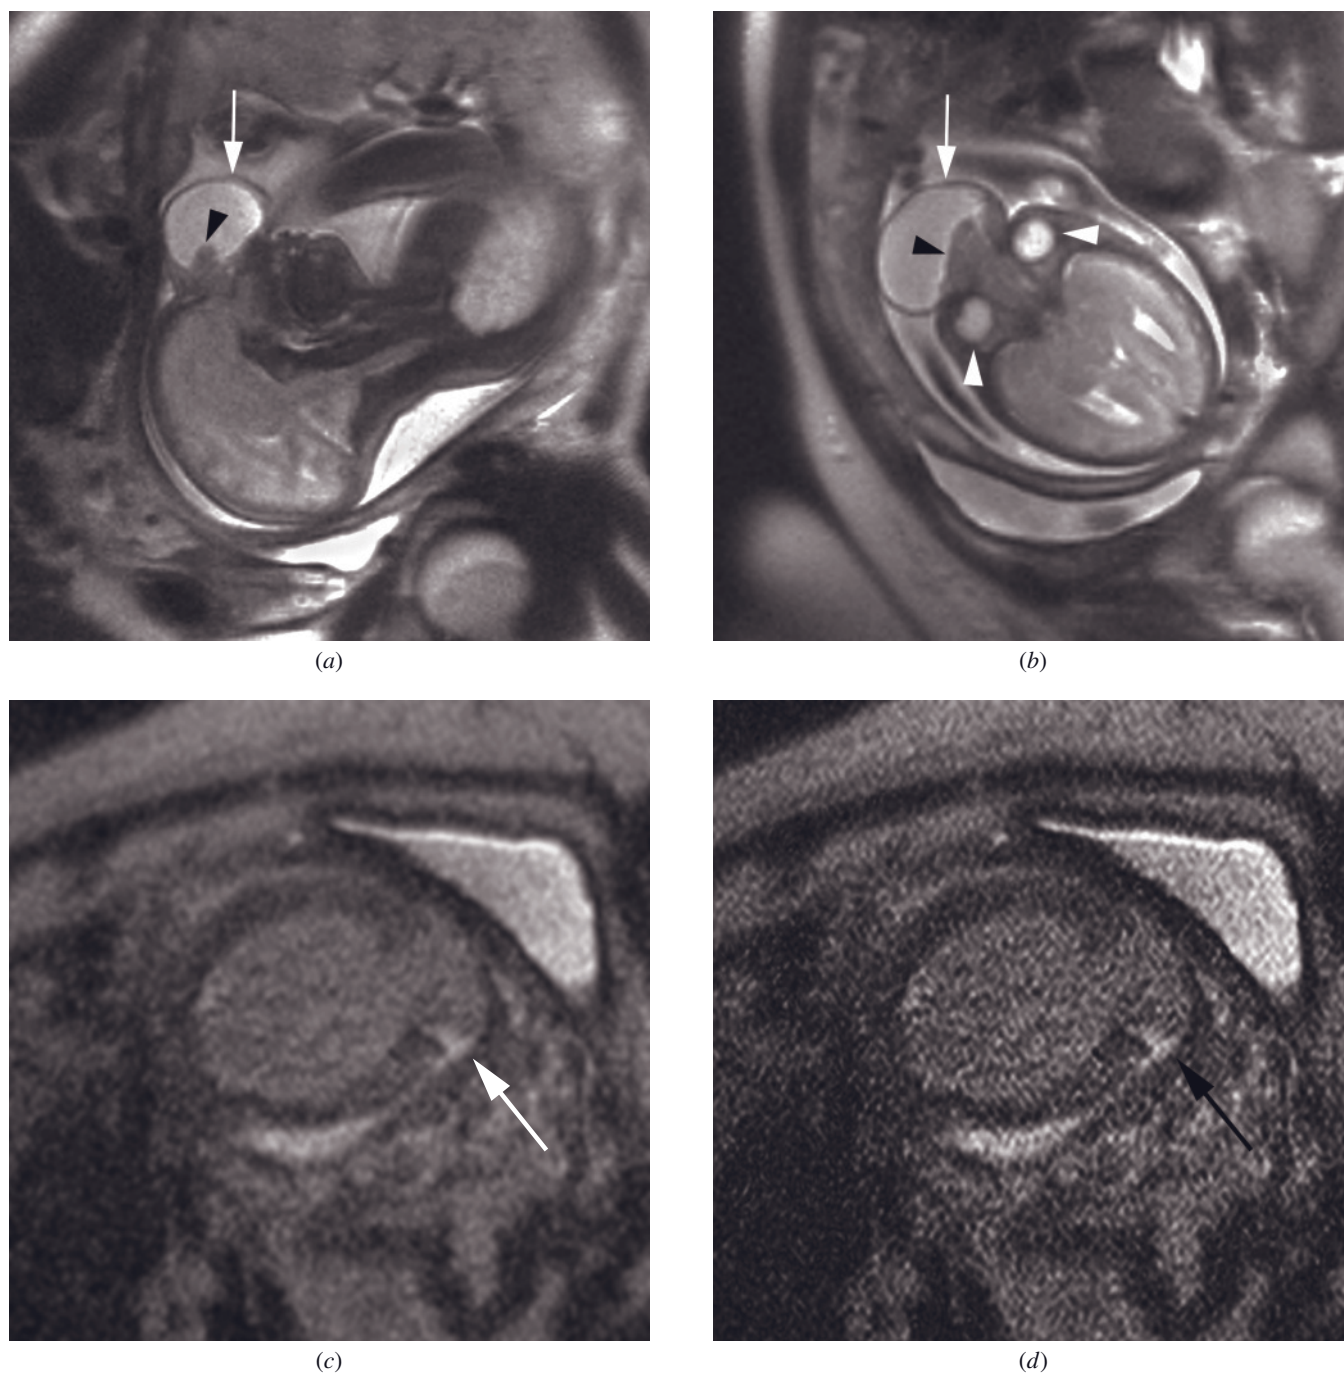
Encephalocele. Sagittal (*a*) and transverse (*b*) T2-weighted SS-ETSE images through the fetal head show a frontal encephalocele. A round fluid-filled structure (arrow, *a*, *b*) is seen anterior to the fetal orbits (white arrowheads, *b*) and face. Intermediate signal intensity within the lesion (black arrowhead, *a*, *b*) continuous with the fetal brain indicates that the encephalocele contains neural tissue. Occipital encephalocele (*c*, *d*) in a fetus at 34 weeks. A posterior calvarial defect is demonstrated, with herniation of brain tissue through the defect (arrows).
